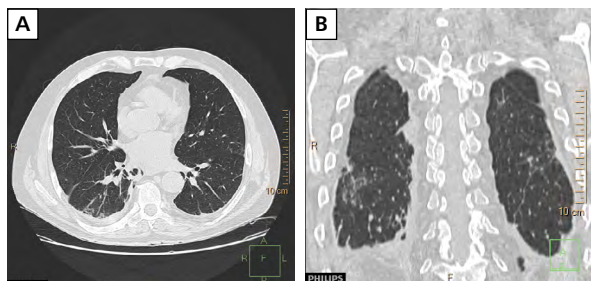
Non-contrast computed tomography of the chest lung window was performed on the 9th day of treatment. The partial regression of pulmonary changes in keeping with COVID-19 infection are visible — subpleural fibrotic changes and moderate pleural effusion; A. Axial scan; B. Coronal scan
